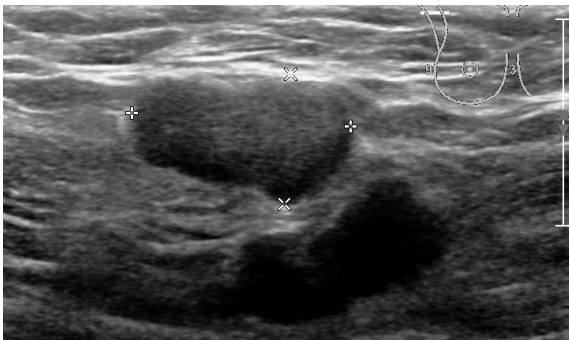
Ultrasound examination showed an enlarged axillary lymph node.
